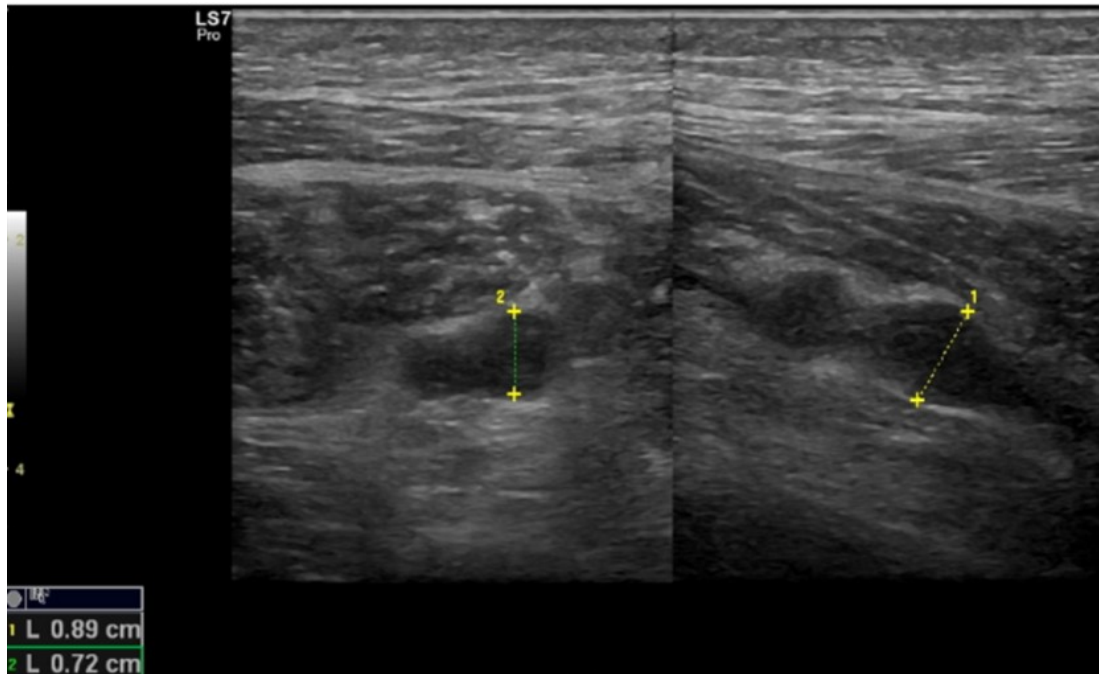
Non-compressible, dilated (to 9 mm) soleal-muscle veins — ultrasound features of intramuscular venous thrombosis.
